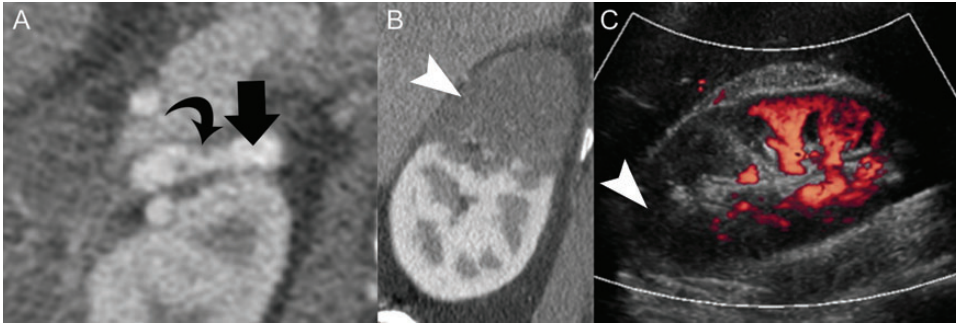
(Case#5) A 40-year-old male with congestive heart failure and Poland syndrome. Coronal maximum intensity projection image from a CT angiography of the abdominal aorta (A) shows dissection flap (curved arrow) and aneurysmal dilatation (arrow head) of the left renal artery (arrow).
